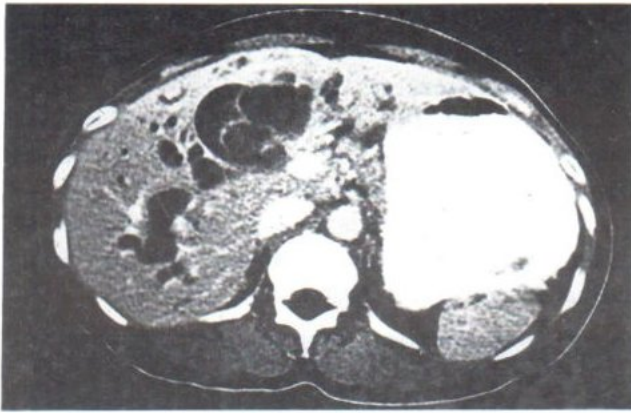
Axial CT showed a multiloculated cystic mass with variable attenuation contents, nodular thickening of septa and a coarse calcification (arrow) in the common hepatic duct. Intrahepatic duct dilatation was also noted.
